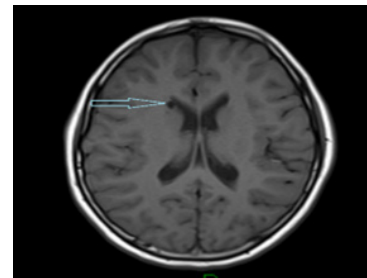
The MRI brain scan T1-weighted image showed a small sub-ependymal cyst (6.1 x 5.6 x 5.7 mm) attached to the upper border of the frontal horn of the right lateral ventricle that showed similar cerebrospinal fluid (CSF) signal intensity in all sequences with no mass effect (November 2019).
